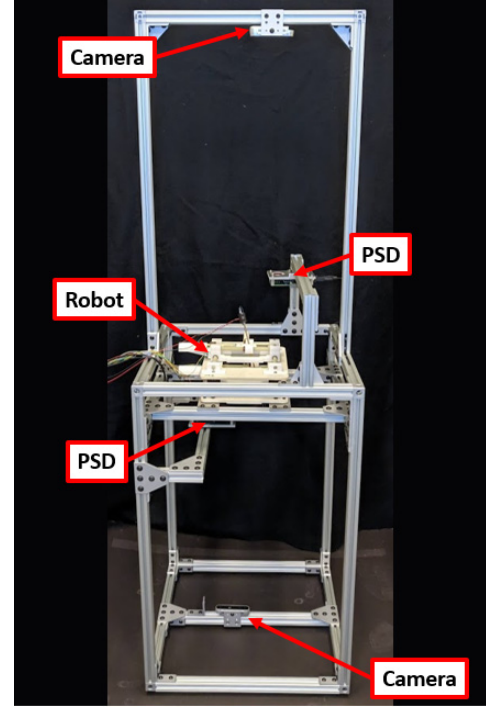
Benchtop experimental set-up to imitate MRI procedure.
